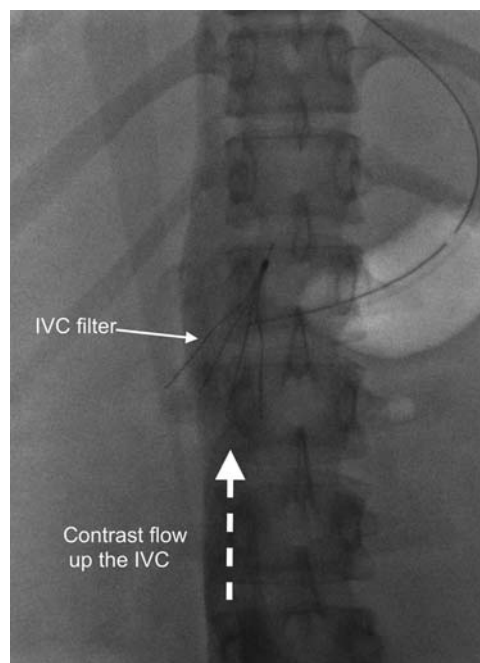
A patient with deep vein thrombosis and recurrent cerebrovascular accidents. A venogram of the intracardiac echocardiography (ICE) showing flow through the inferior vena cava (IVC) filter. An ICE catheter was advanced carefully through the filter and the PFO closure was performed.
